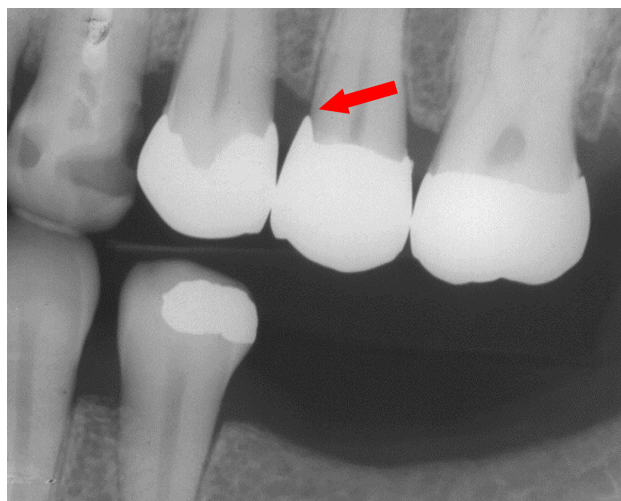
Interproximal radiography of biologic width invasion by overextending margin restoration.
